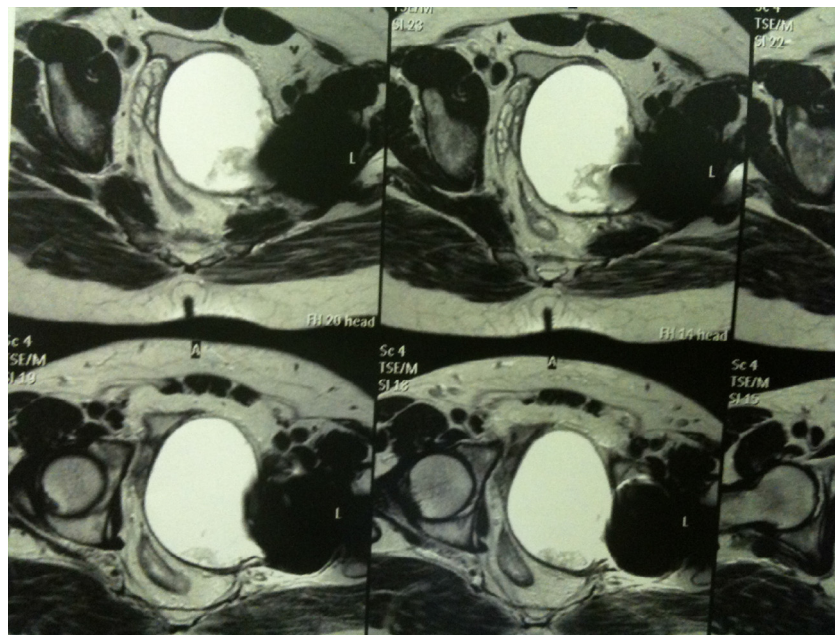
Magnetic resonance imaging in sagittal view with T1 weighting, showing presence of extra-articular mass of fluid appearance in the pelvis.
